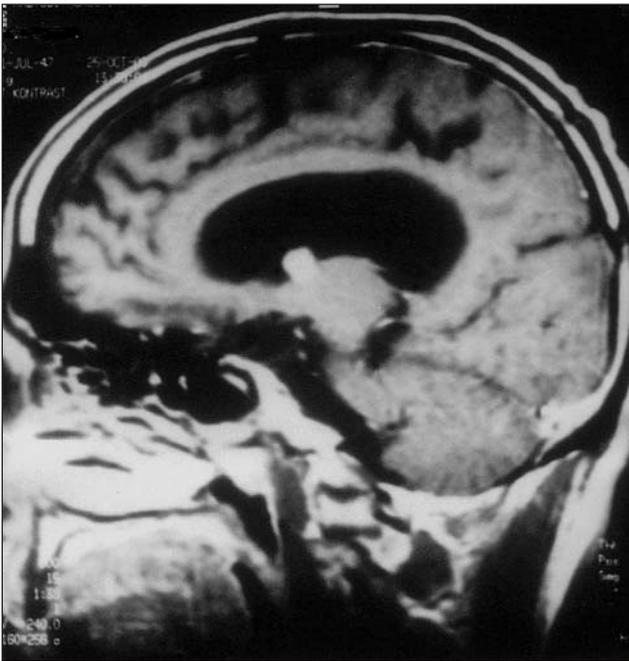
The sagittal MRI scan of the patient showing the mass lesion and hydrocephalus.
